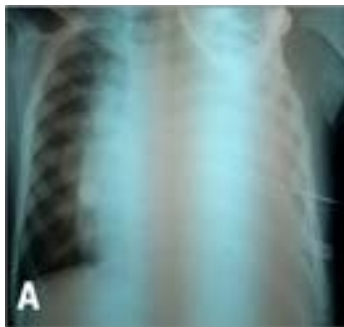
Chest radiograph showing whiteout of the left lung.
